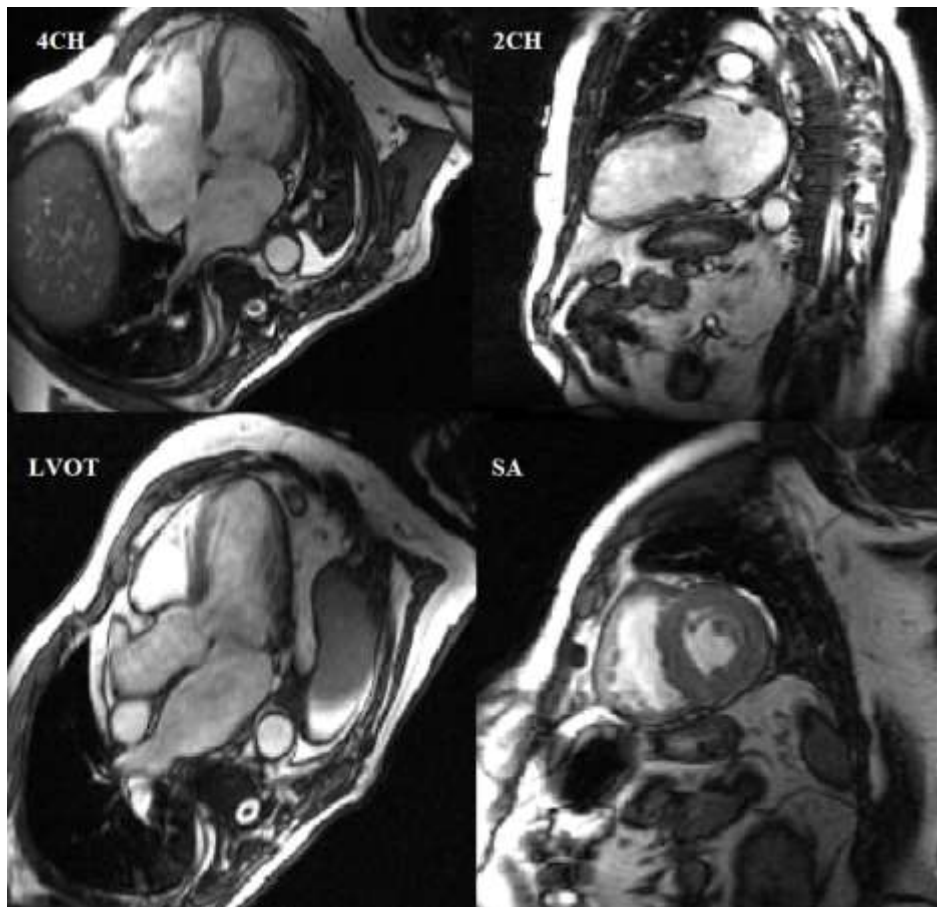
Standard cardiac cine MRI orientations.
